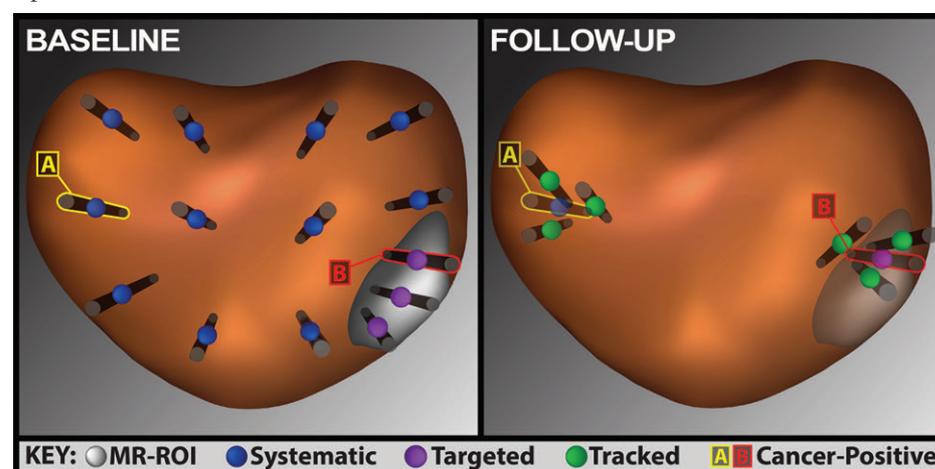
Reconstructed prostate images from fusion device. Gray area is MRI visible region of interest (MR-ROI). Initial biopsy shows systematic (A) and targeted (B) biopsies with cancer containing cores noted. Followup biopsy shows tracked cores obtained from positive site in systematic (A) and targeted (B) biopsy.
